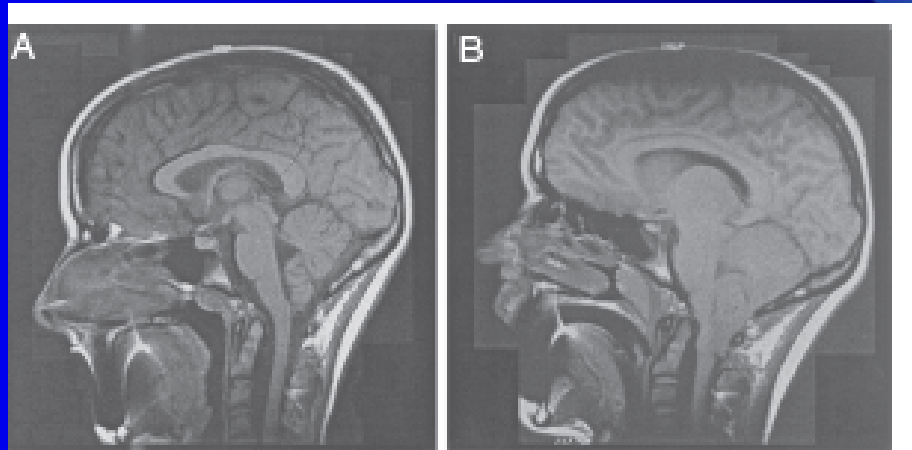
An MRI picture of the brain of a 14-year-old girl suffering from meningitis with raised ICP a few hours after lumbar dural puncture (LP) (B), and 5 weeks later when ICP was normalized (A).
